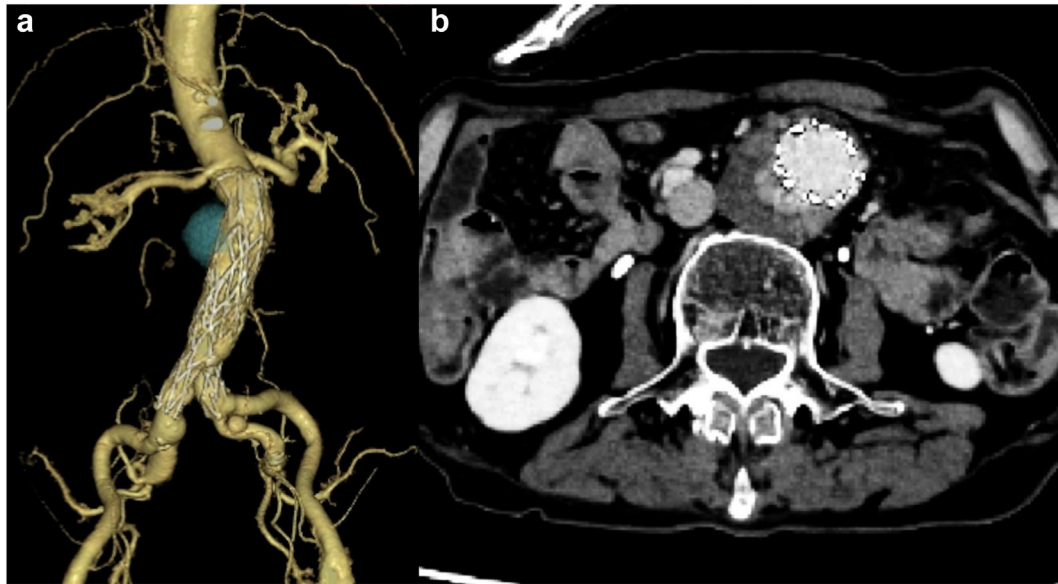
Preoperative contrast-enhanced computed tomography (CT) findings. a, The AFX endovascular abdominal aortic aneurysm (AAA) systems BEA25-90/116-30 and A28-28/C95-O20 V are placed. b, Type Ia endoleak from the dorsal side is observed in the delayed phase.
